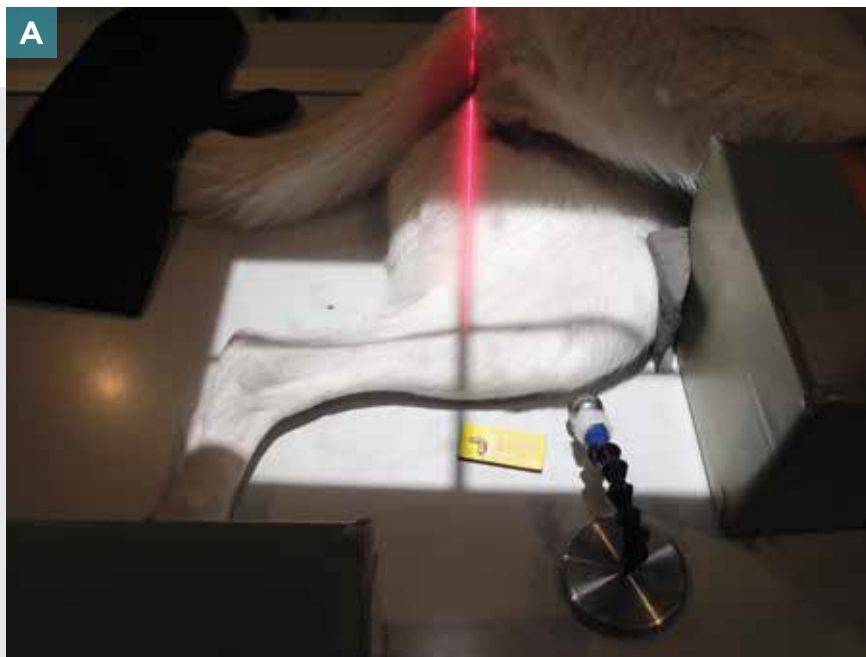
(A) X-ray beam centered incorrectly mid-tibia. (B) Note the poor superimposition of femoral and tibial condyles. Tibial plateau angle (TPA) landmarks are difficult to identify and can lead to overestimation of the TPA.
